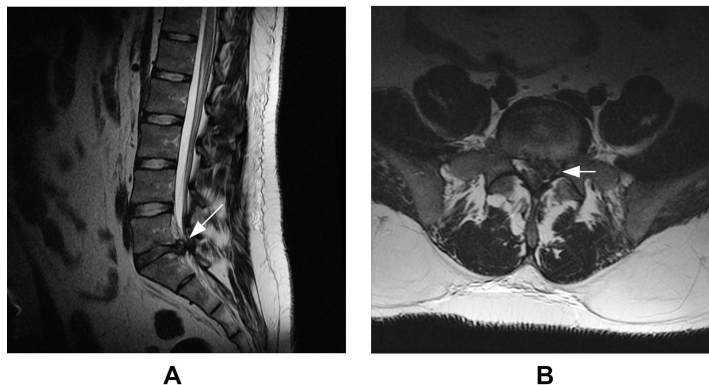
Sagittal (panel A) and axial (panel B) MRI images demonstrating large central and left paramedian disc extrusion at L5-S1 (arrows) with compression on the cauda equina.
